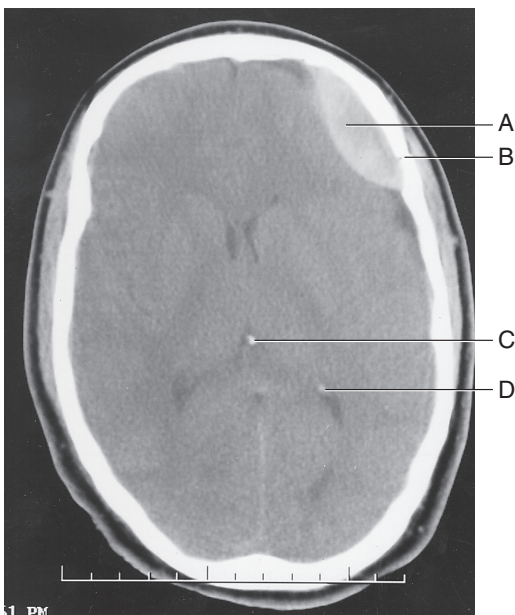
CT scan (axial section) showing an epidural hematoma and a skull fracture. The epidural hematoma has a classic biconvex, or lentiform, shape. (A) Epidural hematoma; (B) skull fracture; (C) calcified pineal gland; (D) calcified glomus in the trigone region of the lateral ventricle.
